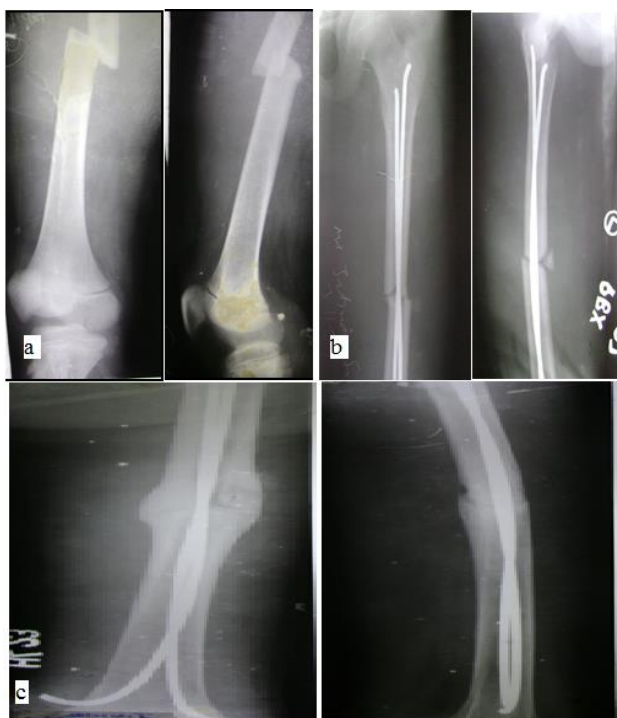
(a) Pre-op X-ray of a 10 years old child showing mid-shaft transverse fracture femur, (b) immediate post-op X-rays, (c) 6 weeks follow up X-ray showing good callus formation and union.
